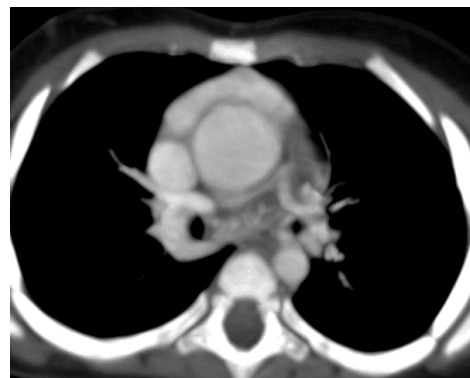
CTA axial image showing multiple MAPCAs.
